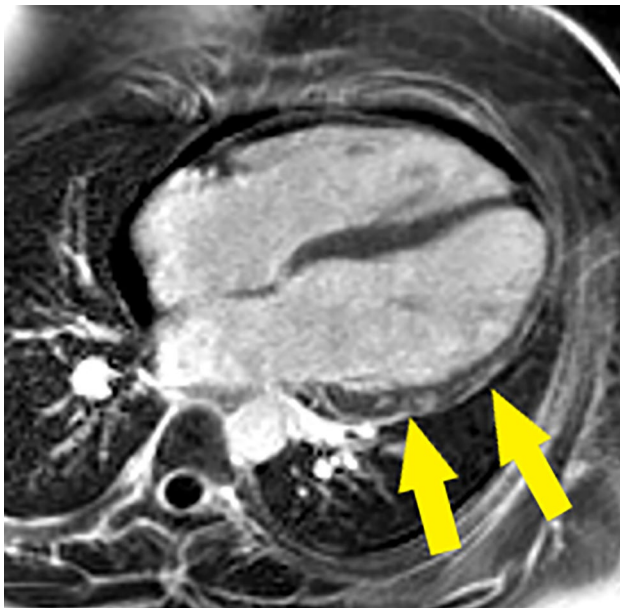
This is a cardiac MRI late gadolinium enhancement (PSIR) long axis image in a patient with a history of MIS-C. There are areas of hyperenhancement (arrows) in a mid-myocardial pattern consistent with myocarditis. The cardiac MRI was performed in the acute presentation of MIS-C, 4 weeks after COVID-19 infection
